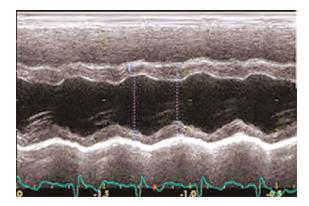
Echocardiography in M-mode
